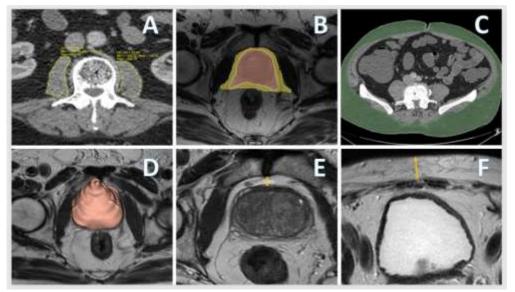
Parameters via MRI (A- Prostate volume, B- Periprostatic fat tissue area, C- Periprostatic fat tissue thickness, D- Psoas muscle density, E- Subcutaneous fat area, F- Subcutaneous fat thickness)
